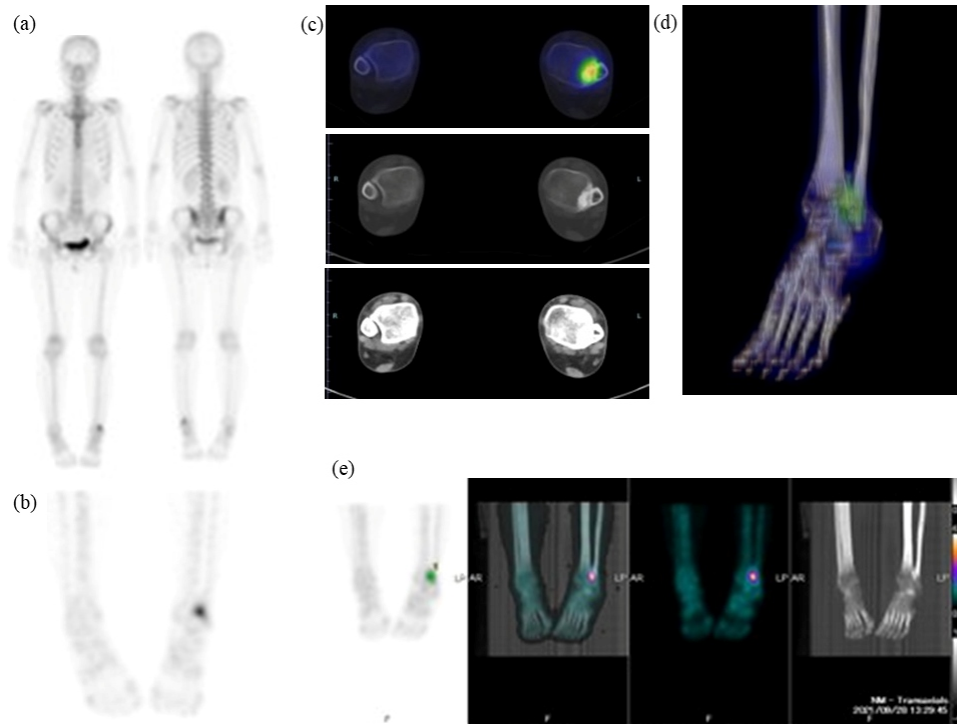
Representative patient; woman (44 years old) with heterotopic ossification of the left ankle. a) Planar bone scintigraphy, b) spot planar view, c) transaxial bone SPECT/CT, and d) 3D-SPECT/CT findings showing weak uptake and heterotopic ossification in the left ankle. e) VOI indicated by the GI-BONE® software package and calculated quantitative values are shown below the images: SUVmax 4.39, SUVpeak 4.15, SUVmean 3.11, MBV 8.33, and TBU 25.90. Based on the relatively low metabolic activity, surgical resection was performed.
